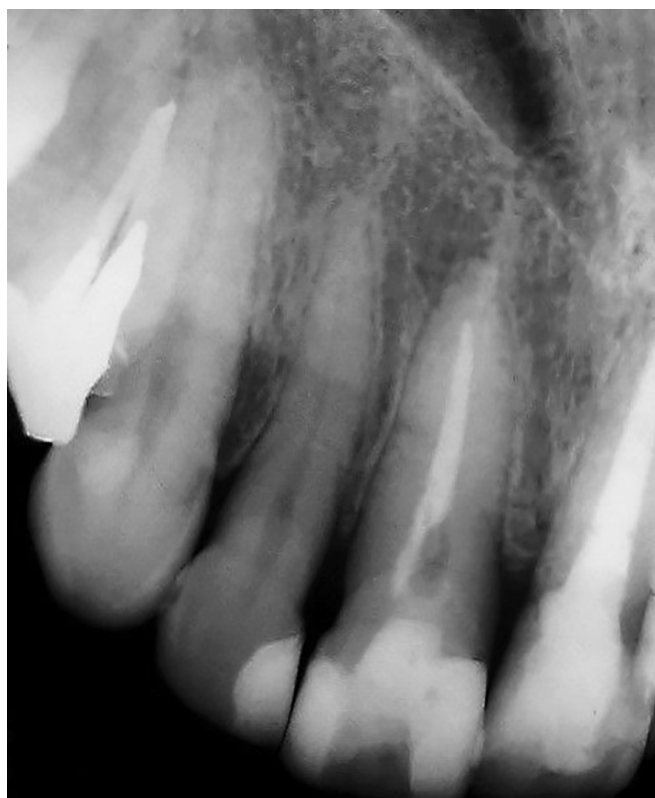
Initial radiograph of tooth #11.
